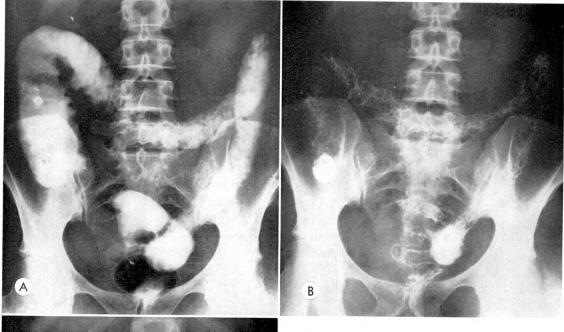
(A) Barium enema study of patient taken in 1954. Unfortunately, earlier roentgenograms, which showed the same findings, are not available. On this roentgenogram, in which the colon is filled with barium, note the lack of foreshortening of the colon which one would expect to see with long standing ulcerative colitis with pseudopolypi formation. However, there is apparent rigidity and scalloping of the mucosa between the numerous polyps, as is commonly seen in lymphoma. (B) Postevacuation roentgenogram taken as part of the same study. The polyps are again seen, extending into, but not apparently below, the sigmoid colon. Note the ulcerating cecal lesion described at autopsy. (C) Post evacuation roentgenogram from a repeat study done on patient in 1959. Note the same appearance of the colon and the lack of foreshortening, despite presence of the disease for at least 14 years.
